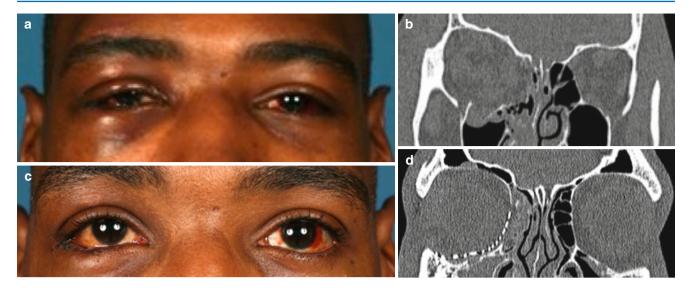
CT evaluation is now commonly undertaken for both pre- and postoperative assessment of the orbit following trauma (a–d). Such a large two-wall defect as shown is a very difficult fracture to precisely repair. Postoperative clinical examination will give no indication of long-term outcomes, but a CT showing a correctly positioned plate is certainly reassuring. If the plate is incorrectly placed, the patient may need to return to theatre
